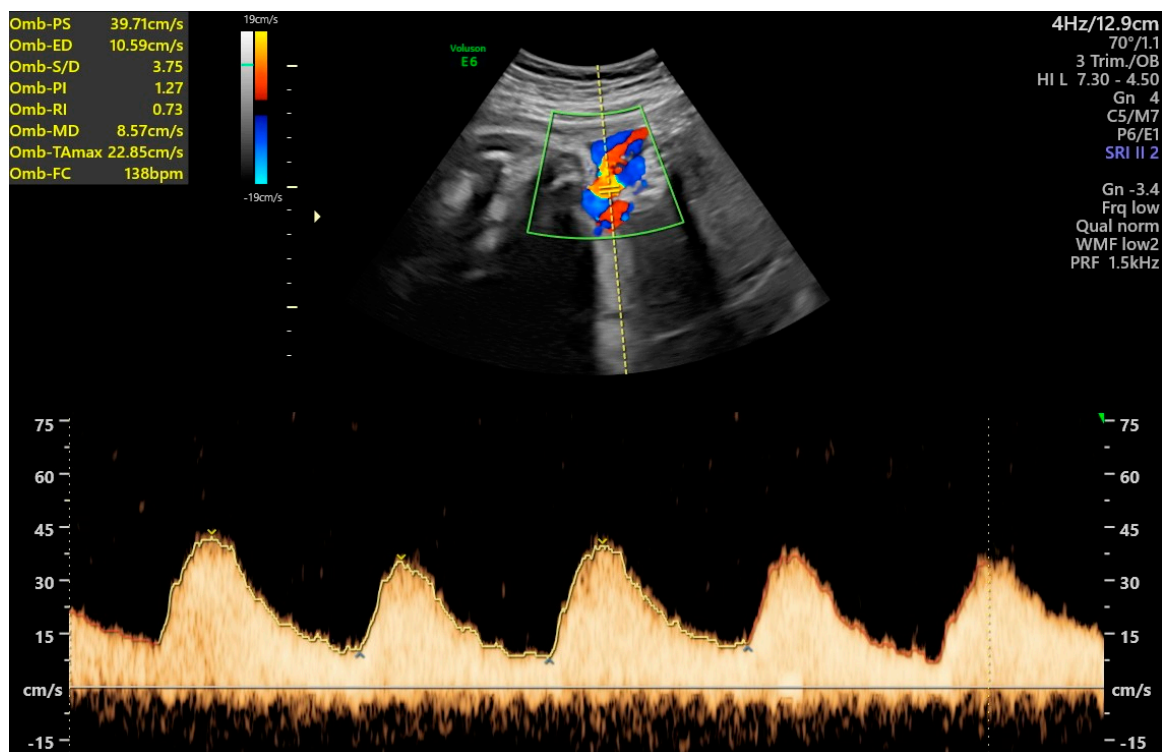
Ultrasound Doppler of the umbilical artery pulsatility index at 34 weeks and 6 days.
